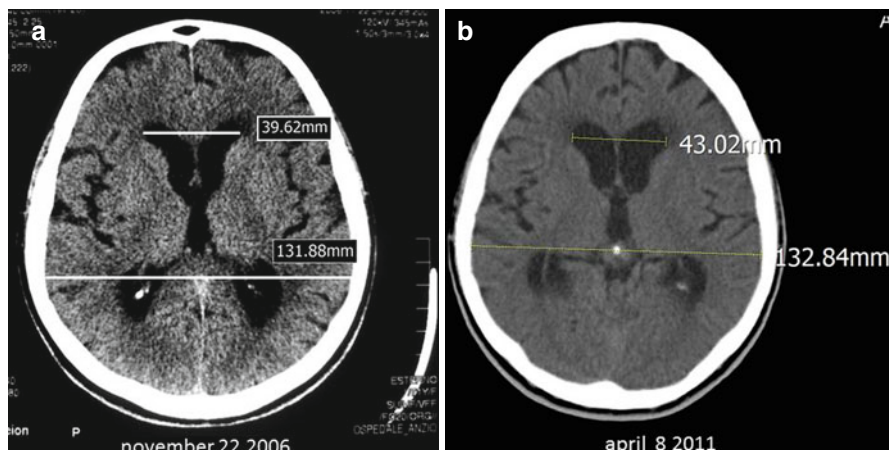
(a) A 72-year-old female with gait instability. CT scan shows Evans' index of 39.62 mm/131.88 mm=0.30. (b) The same patient after 55 months complaining short memory impairment, recurrent falls, and urgent urination. On control CT scan the frontal horns appear more enlarged with Evans' index increase: 43.02 mm/132.84 mm=0.32
